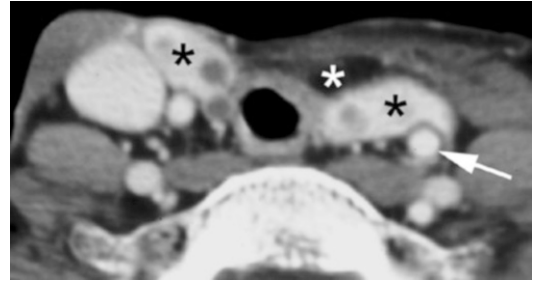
Axial contrast-enhanced CT image. The neopharynx is seen lying between both thyroid lobes (black asterisks). The thyroid isthmus was resected during the laryngectomy. The inhomogeneous appearance of the thyroid lobes is caused by nodular hyperplasia. Absence of left internal jugular vein along the common carotid artery (arrow), resected during radical neck dissection. Soft tissue flap (white asterisk)
